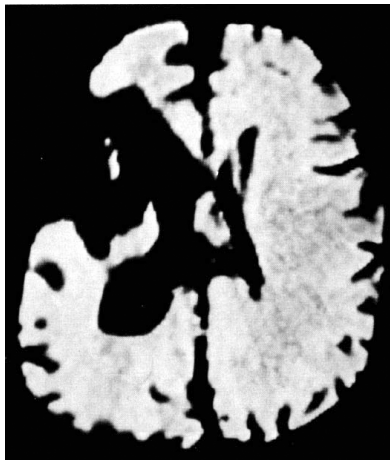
CT-scan of original brain of Broca's patient Monsieur LeBorgue (adapted from Castaigne, Lhermitte, Signoret & Abelanet, 1980).
